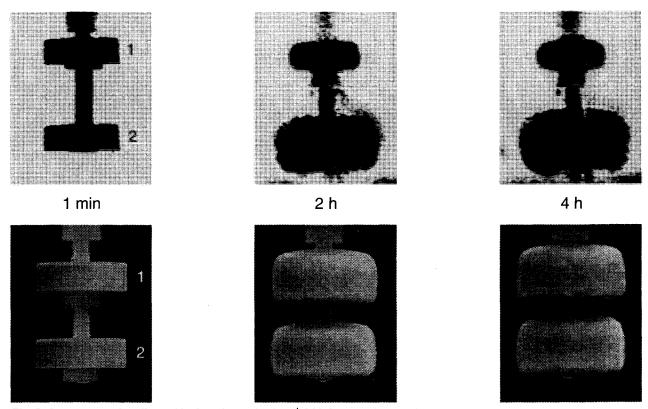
Investigation of swelling tablet formulations in vitro: ¹H-MRI versus photography
